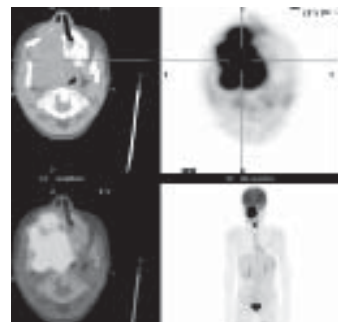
A typical PET/CT
